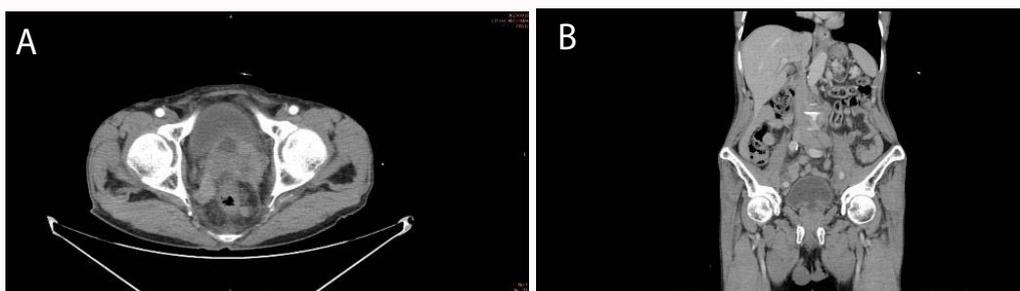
Contrast computed tomography (A) Axial view showed rectum invasion (B) Para-aortic multiple nodal involvement.
